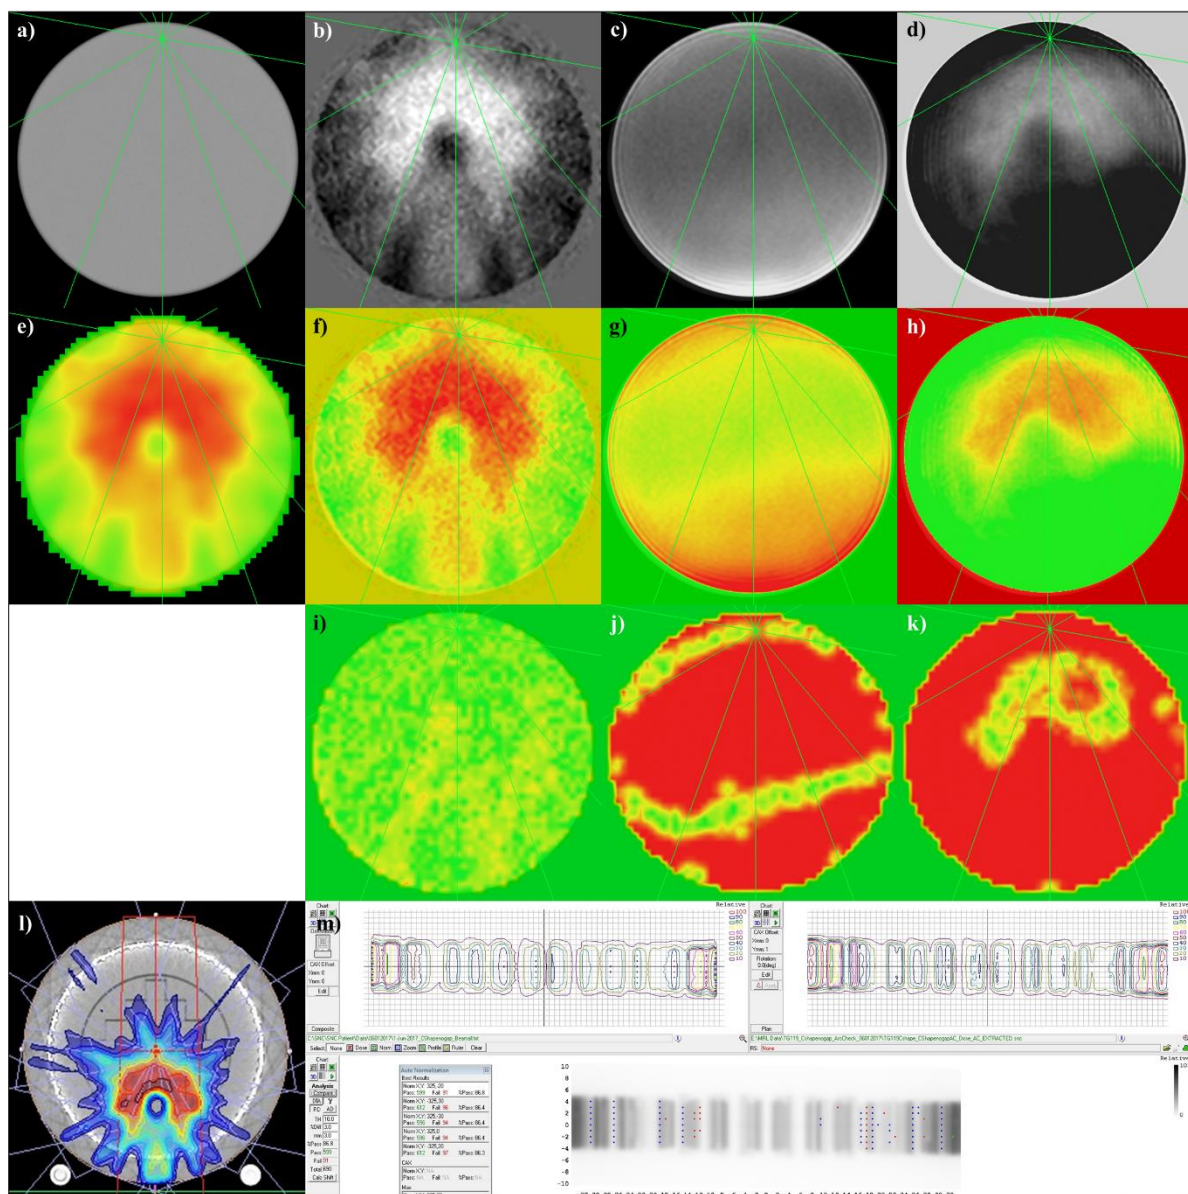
a) CT of large uniform FXG, b) T1-weighted T1 CE image, c) T1-weighted no CE image, d) T2-weighted image, e) Monaco TPS dose overlaid on CT, f) T1 CE relative dose, g) no CE relative dose, h) T2-weighted relative dose, i) gamma map of T1 CE dose, j) gamma map of no CE dose, k) gamma map of T2-weighted dose, l) Monaco TPS dose on CT of ArcCHECK-MR, and m) delivered and planned relative dose comparisons for C-Shape TG-119 plan.
